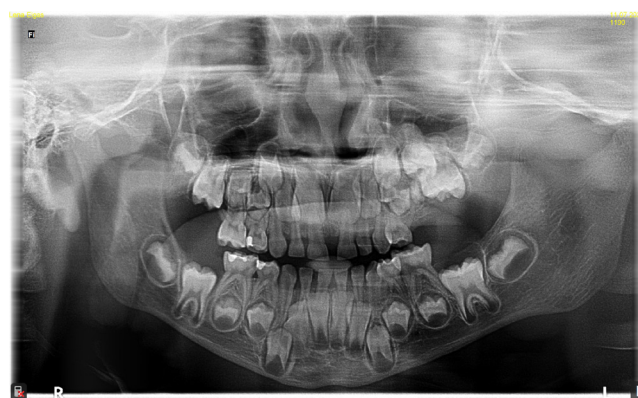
Panoramic radiograph with impacted deciduous tooth 65 and a compound odontoma (OCp) in a 5-year-old patient
